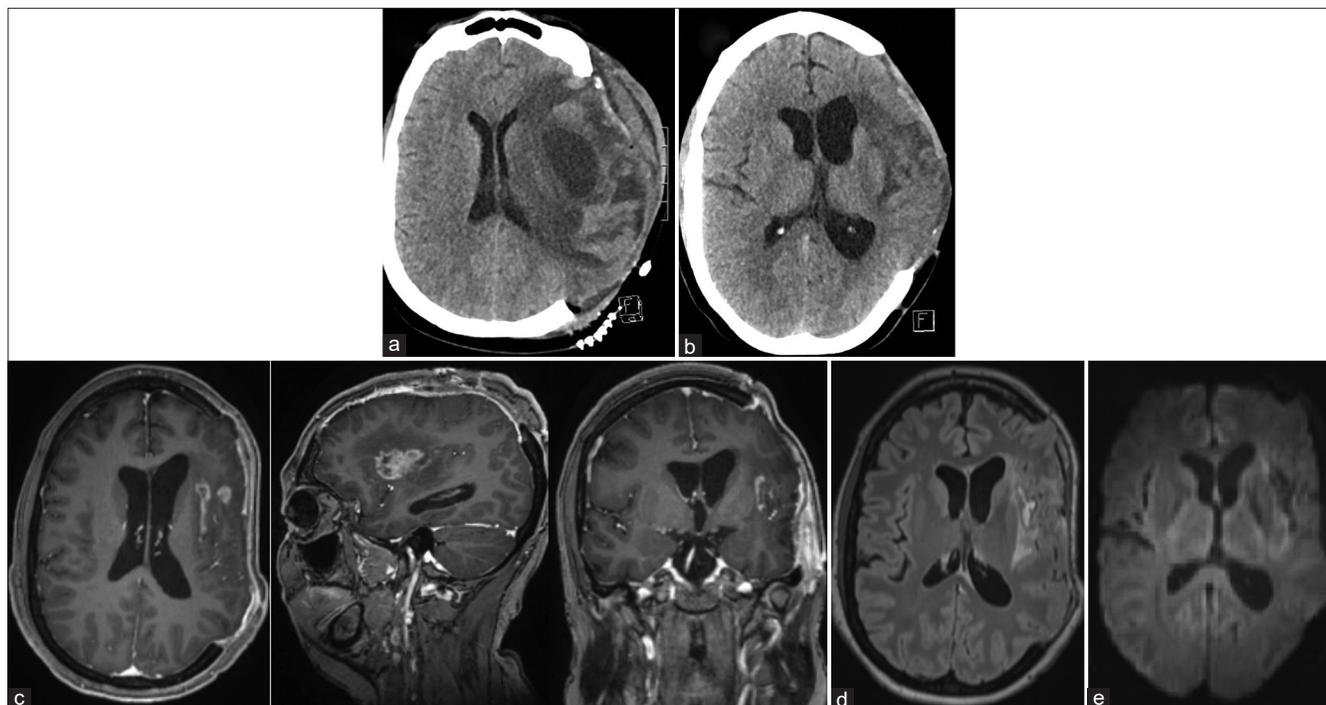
(a) Postsurgical changes from left-sided craniectomy with extensive edema of brain parenchyma causing herniation of the left cerebral hemisphere through the craniectomy defect, minimal rightward midline shift, and effacement of the left lateral ventricle. (b) A follow-up scan 2 months after discharge shows improving cerebral edema and no abnormal enhancement to suggest persistent or recurrent abscess. T1 postcontrast axial, sagittal, and coronal (c), axial fluid-attenuated inversion recovery (d), and axial diffusion-weighted imaging (e) sequences from her most recent follow-up MRI taken 3 months after discharge shows substantially decreased brain herniation and swelling of the left cerebral hemisphere with residual enhancement within the insula and mild residual FLAIR hyperintensity involving the left frontal lobe, insula, and left temporal lobe.
